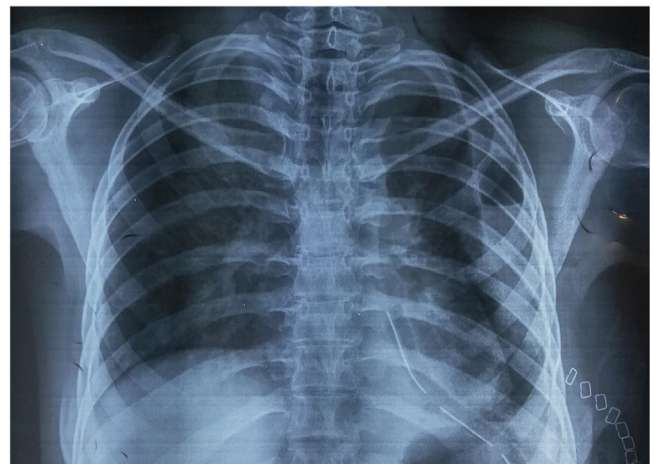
Post operative Chest Xray with chest tube in situ.
